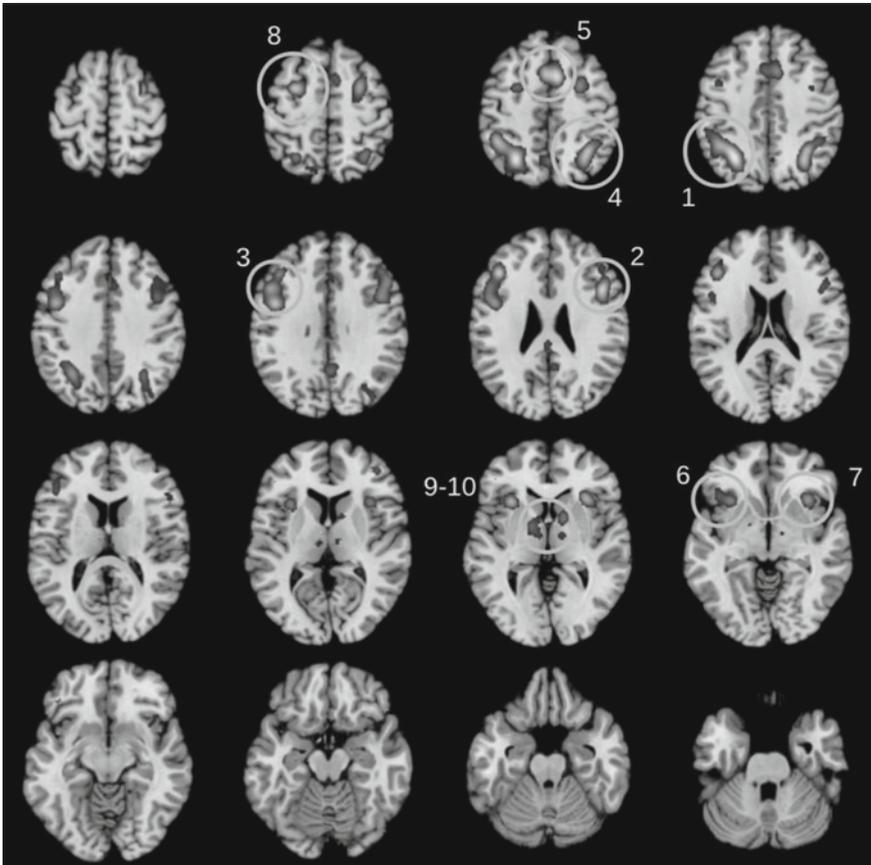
Reasoning: functional connectivity map using meta-analytic connectivity modeling. Sixteen transversal descending cuts have been selected from the brain MRI anatomical volume. Left hemisphere appears on the left side (neurological convention). Clusters are gray-coded for intensity. Main clusters are circled at the most representative level and numbered according to their respective cluster number. *Note* Some areas belonging to the same cluster may appear disconnected due to the discontinuity of the sampling cuts (reproduced with permission)
